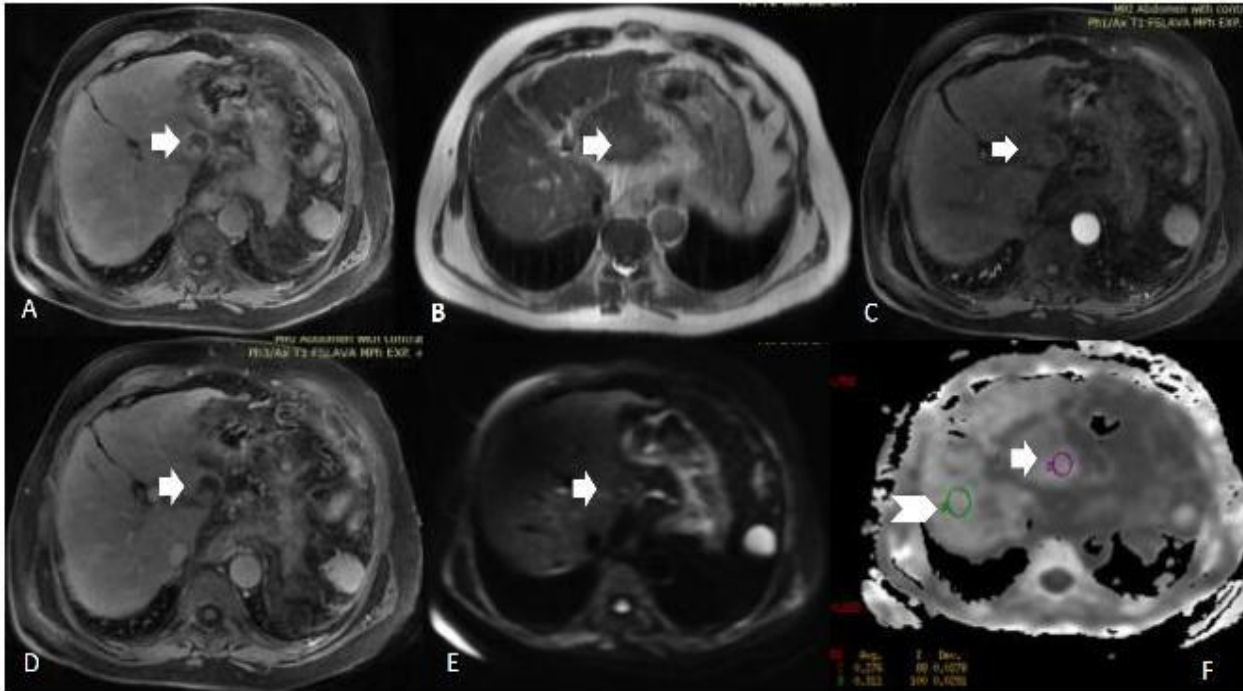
Axial MRI images at the level of the embolized lesions A)T1 weighted image showed heterogeneous predominantly low signal intensity. B) T2 weighted image showed low signal intensity of the lesion. C and D) Dynamic MRI arterial phase and equilibrium phase both showed no evidence of contrast uptake. E) DWI at b value 20 showed no evidence of diffusion restriction. F) ADC value showed high DC value ((measuring about 2.9×10^{-3}) arrow compared to the normal liver parenchyma measuring about (2.7×10^{-3}) arrow head).
